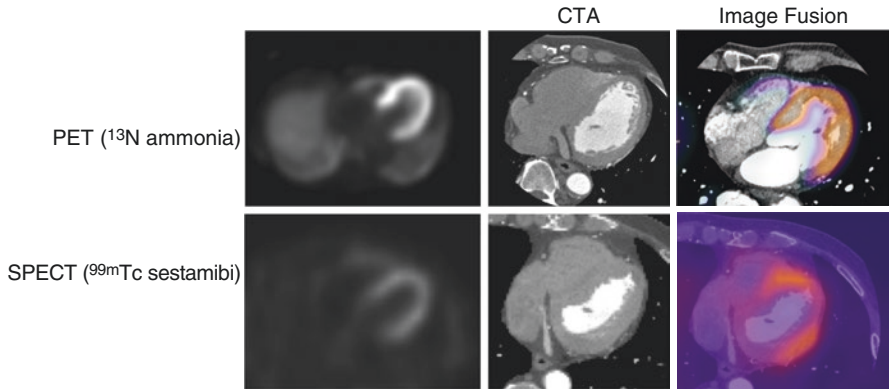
The figure shows comparison of image fusion for CTA and PET or SPECT. Panels show transaxial view of each modality. Upper shows ^{13}N ammonia PET, CTA, and image fusion. Lower shows $^{99\text{m}}\text{Tc}$ sestamibi SPECT, CTA, and image fusion. Using high-resolution PET, image fusion to CTA is obviously feasible due to both RV and LV are visual, while it is occasionally challenging due to lower contrast and blur contour in SPECT images
